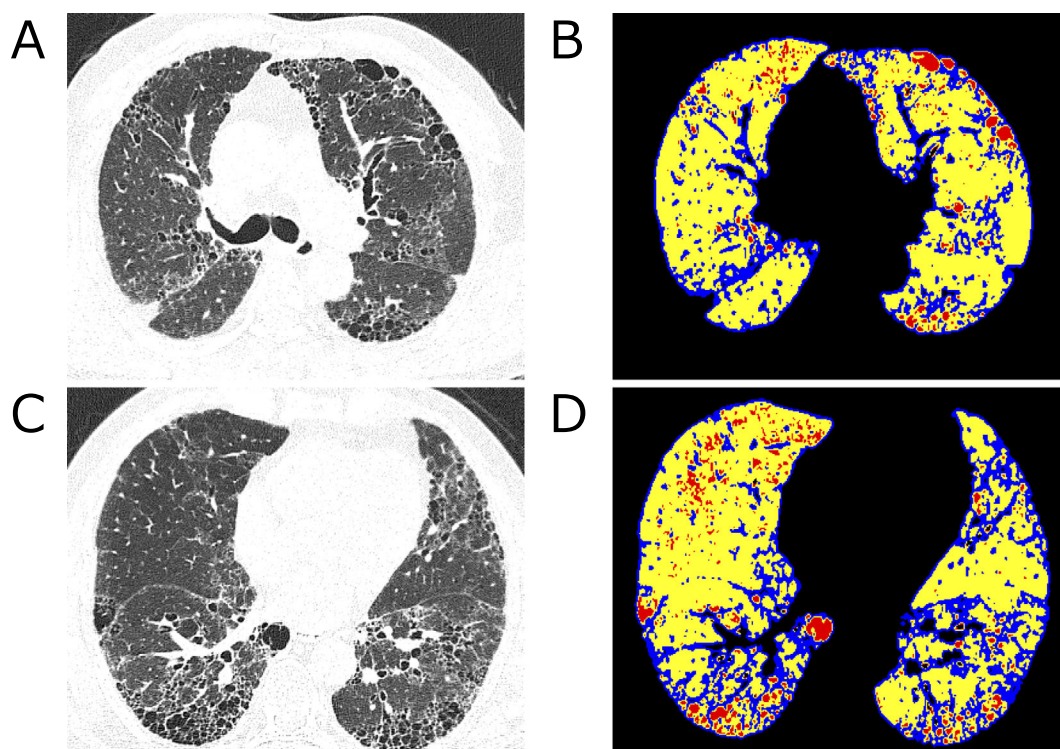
High-resolution computed tomography images with the normally attenuated areas identified (A and C). High-resolution computed tomography (HRCT) chest images of a 72-year-old man with idiopathic pulmonary fibrosis (B and D). The same images, colored as follows: yellow, normally attenuated lung [defined as -950 to -701 Hounsfield units (HU)]; red, areas of low attenuation (lower than -950 HU); blue, areas of ground-glass attenuation and consolidation (higher than -701 HU). This patient's whole-lung volume by volumetric HRCT analysis was 3,323 mL, and the volume of normally attenuated lung was 2,170 mL. Thus, the normally attenuated lung volume as a percentage of the whole-lung volume (NL%) was 65.3%.
